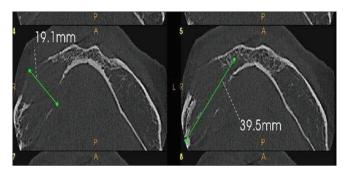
Cone-beam computed tomography showing bicortical expansion in the axial overview
